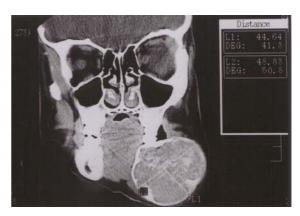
Preoperative computerized tomography (CT) view.
